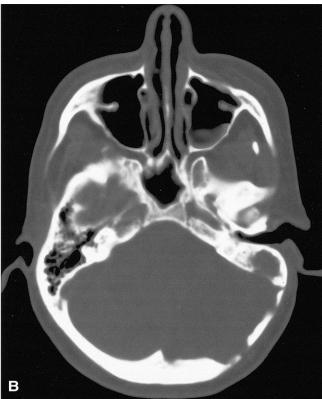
(A). CT scan demonstrating posterior fossa mass, intracranial air, and erosion of temporal and occipital bones. (B) CT bone windows demonstrating bony erosion.
